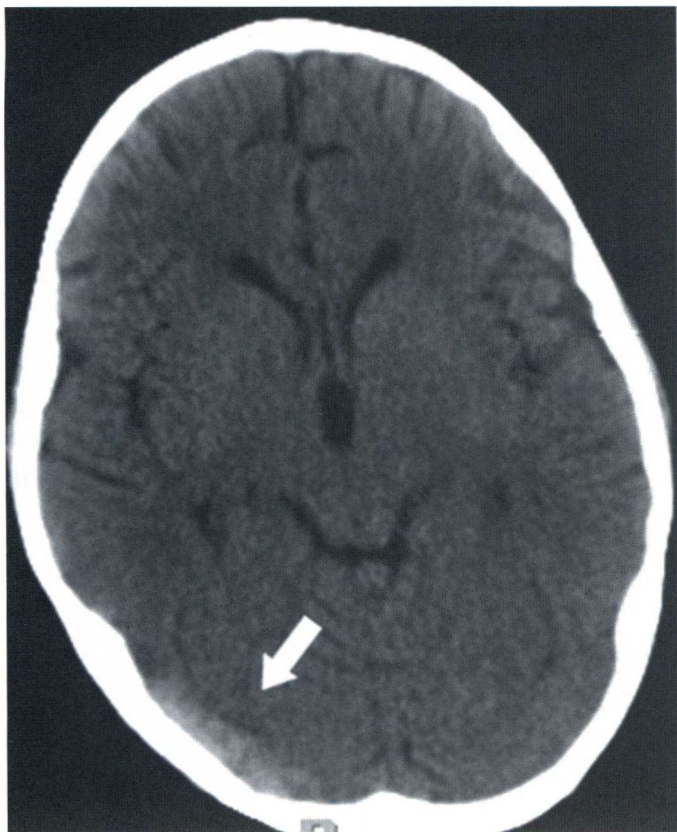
Axial CT shows a marked hyperattenuation in the right transverse sinus, which was confirmed to represent acute thrombosis.
